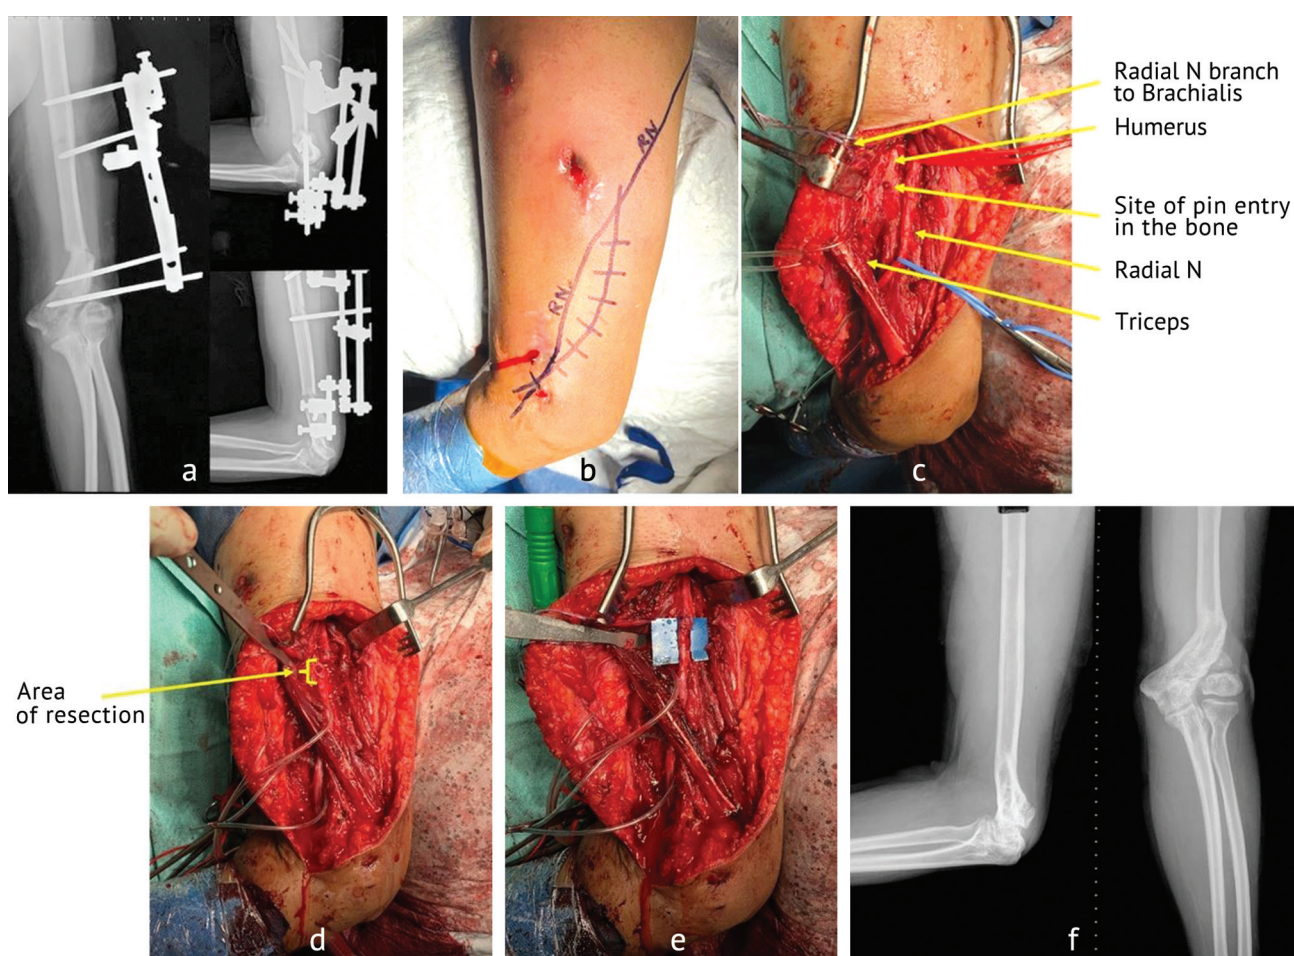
Case of a 24-year-old male with cubitus valgus: (a) post-operative radiographs following mini-Ilizarov correction; (b) skin marking for radial nerve exploration; (c) intra-operative findings during exploration, showing the pin entry into the bone, immediately adjacent to the neuroma; (d) resected non-conducting segment, as determined by nerve stimulation; (e) end-to-end epineural repair, reinforced with Tisseal® fibrin sealant; (f) final follow-up radiographs showing satisfactory consolidation and limb alignment
